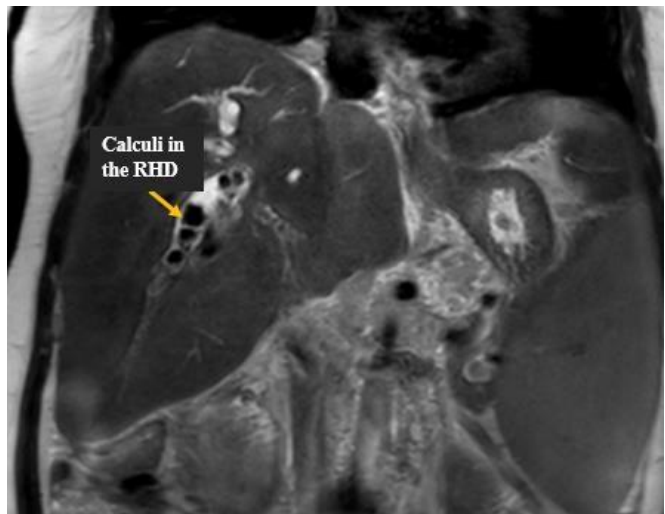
T2 MRI coronal image. Multiple calculi are seen in the RHD
